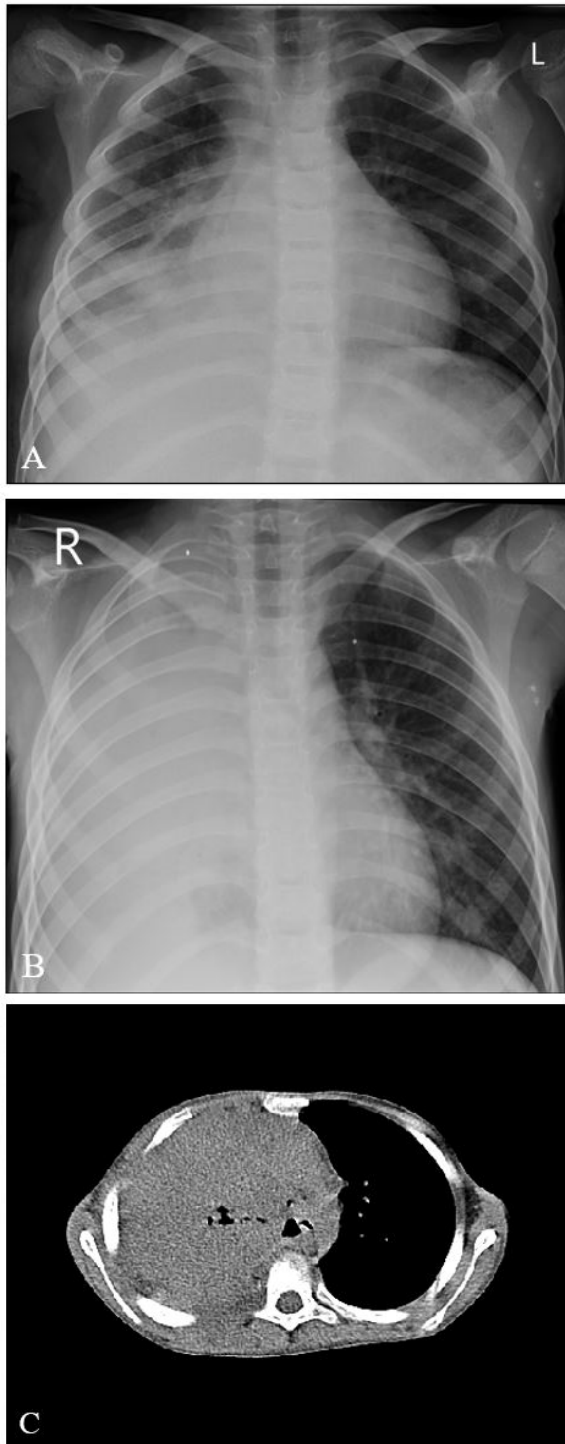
A) First chest X-ray of the patient at the first hospitalization showing opacity in the right lung; B and C) CXR and chest computed tomography (CT) scan showing the progression of the lung mass following discontinuation of steroids at 8.5 years old.
